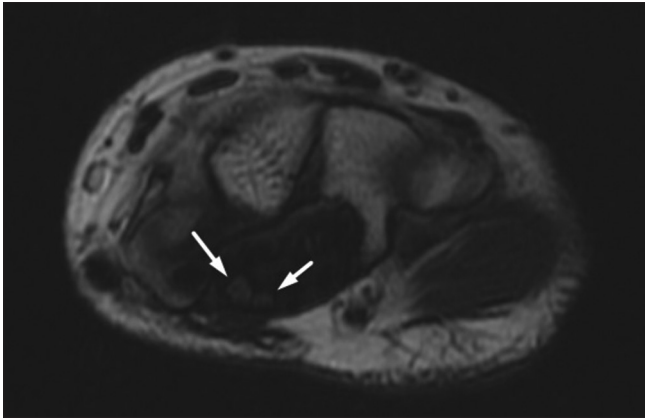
T2-weighted axial image shows the variation of median nerve with two nerves (arrows) in the carpal tunnel (bifid median nerve)
